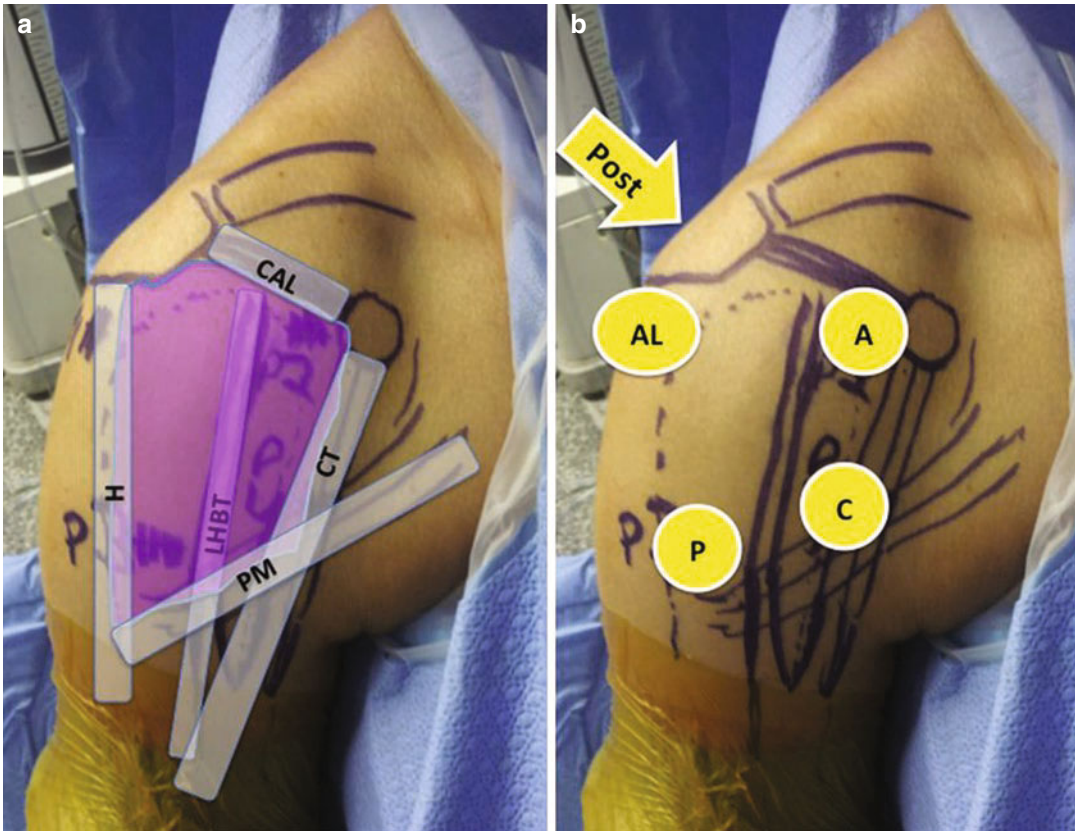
(a) The subdeltoid space (purple) is defined superiorly by the coracoacromial ligament (CAL), medially by the coracoid and conjoint tendon (CT), inferiorly by the pectoralis major (PM), and laterally by the lateral border of the humerus (H). The long head of the biceps tendon (LHBT) exists in the floor of the subdeltoid space. (b) Five portals are used during subdeltoid arthroscopy:
